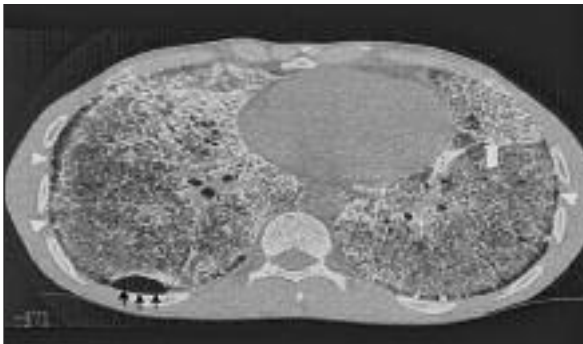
High-resolution CT scan of case 1 showing extensive small subpleural cysts surrounding the entire lung. Some of them (black arrows) coalesce to form a larger cyst. In addition this figure shows the prominence of the fissure (white arrow) and calcific densities predominantly located in the right middle lobe and lingula.
